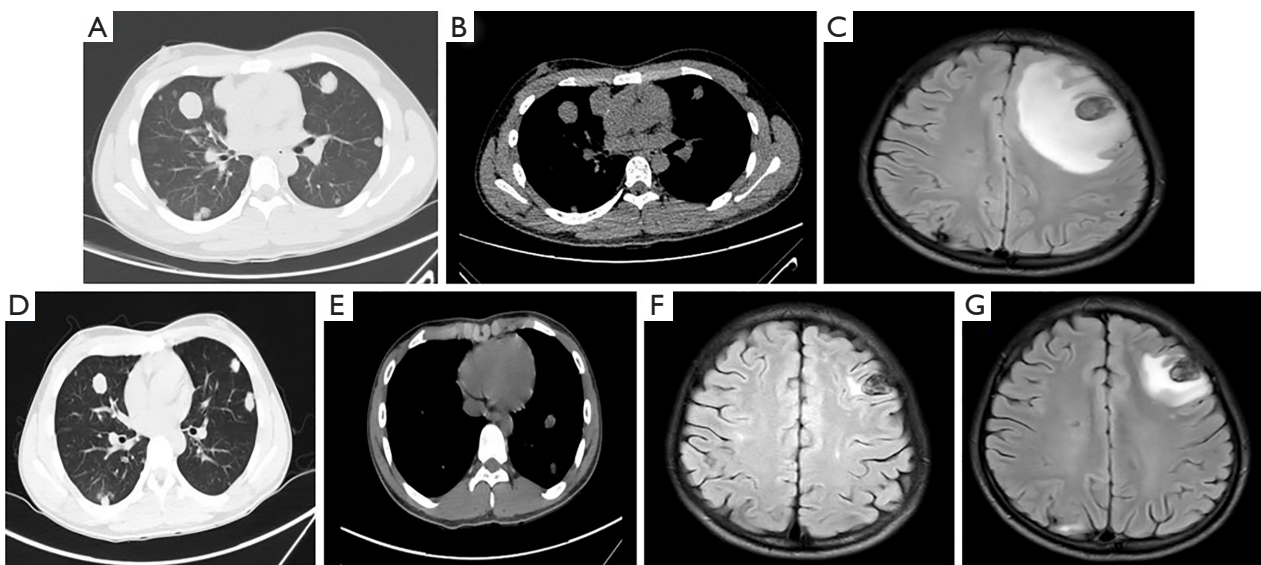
CT/MRI scans evaluate the progression of disease. (A,B) CT scan of the thorax reveals an enlarged anterior mediastinal mass and multiple metastatic lung nodules after the several cycles of chemotherapy. (C) MRI shows brain edema and lesions after chemotherapy. (D,E) Both mediastinal and pulmonary lesions are partially reduced after four cycles of tislelizumab. (F) MRI shows brain edema and lesions after four cycles of tislelizumab. (G) MRI shows brain edema and lesions after six cycles of tislelizumab. CT, computed tomography; MRI, magnetic resonance imaging.
